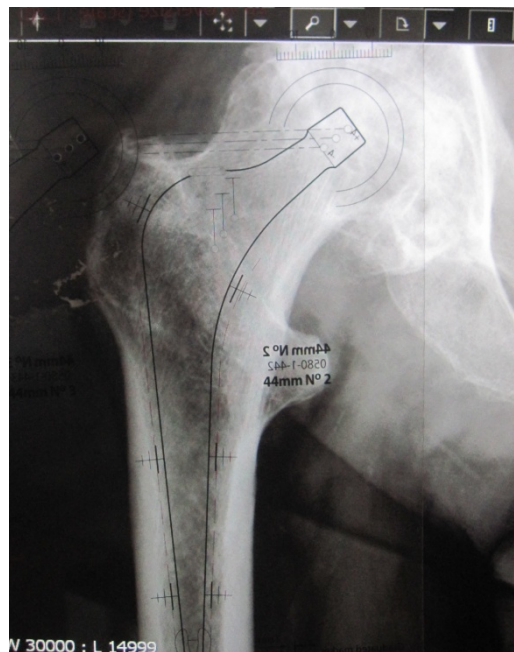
An arbitrary 30mm line is marked on the acetate template ruler and a line 36mm (20% longer to account for image magnification) is drawn on the on screen image using the computer software (a). Using the magnification tool the on screen image is enlarged until the two lines are of equal length (b). The radiograph is now scaled to the acetate template which can then be used for preoperative templating in the usual manner (c).
